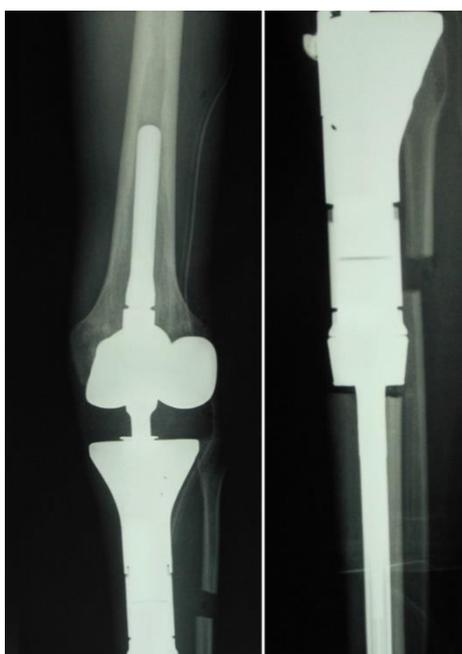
Postoperative X-ray of the reconstruction
